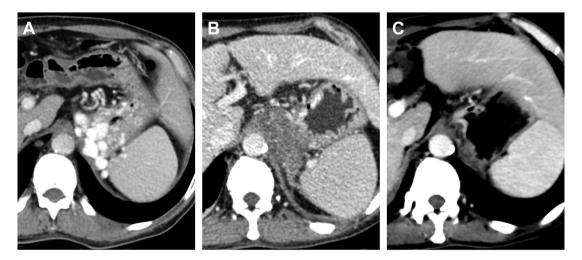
Contrast-enhanced portal-venous phase axial computed tomography images of gastric varices in (A) pre-CARTO (pre-coil-assisted retrograde transvenous obliteration) with huge transmural gastric variceals (GVs) in the gastric fundus with a recent history of acute upper gastrointestinal bleeding, (B) Three-day post-CARTO demonstrating non-enhancing/hypoenhancing gastric fundal wall consisted with completely thrombosed GV, and (C) 3-month post-CARTO demonstrating complete disappearance of GVs with normal gastric fundal enhancement/anatomy.
